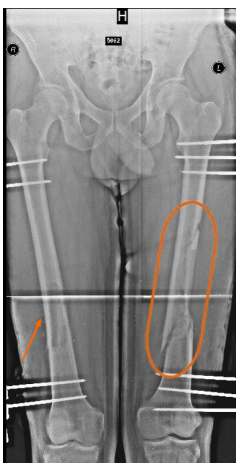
An X-Ray of both thighs with external AO fixation (preventive on the right). Orange arrow shows sequestrum, orange circle indicates osteosynthesis after fracture with displacement.
